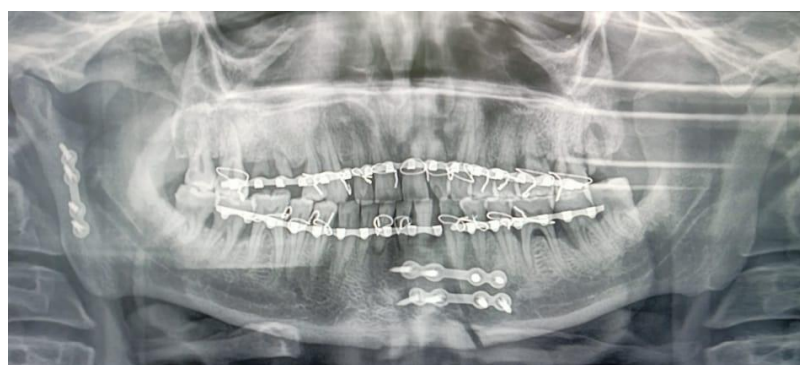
showing postoperative orthopantomogram
